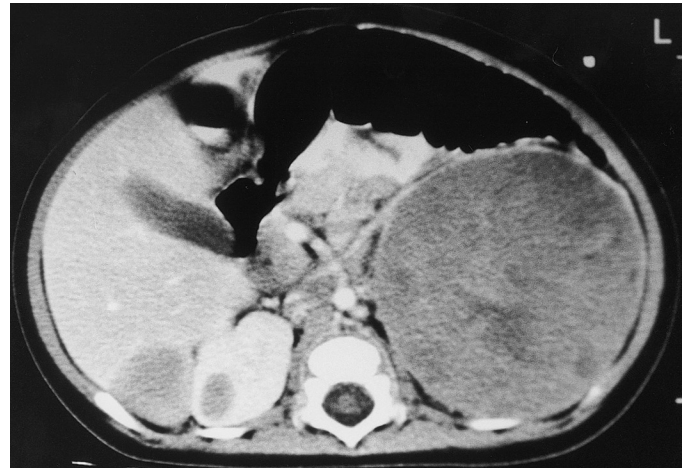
Computed tomogram of a left adrenal neuroblastoma reveals metastatic disease in the right kidney and liver. The patient, in whom the disease was diagnosed before 1 year of age, died of the disease.
